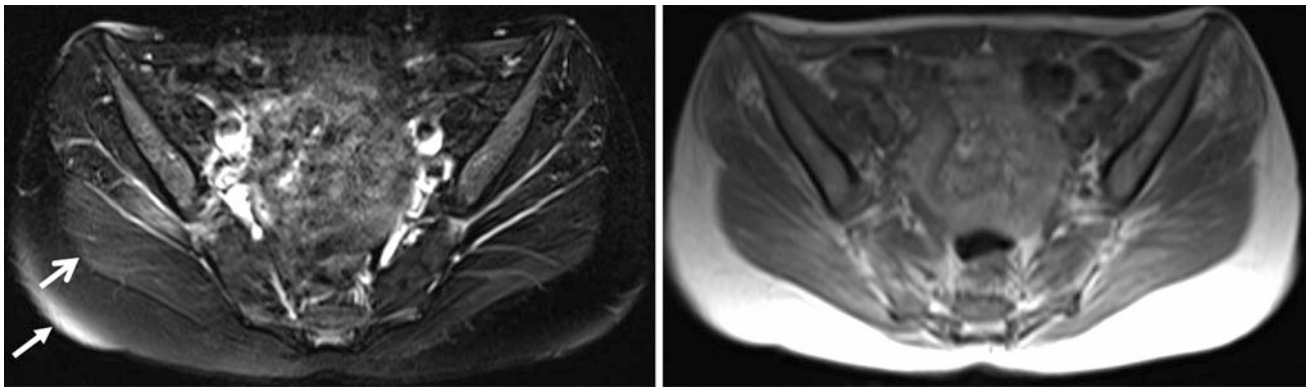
Axial T1-weighted images (*right*) and fat suppressed T2-weighted images (*left*) at the pelvis region from a patient with suspected myotonic dystrophy. The areas with high signal intensities in the subcutaneous fat (*closed head arrow*) and in the adjacent gluteus maximus muscle (*open head arrow*) are based on inhomogeneous fat
